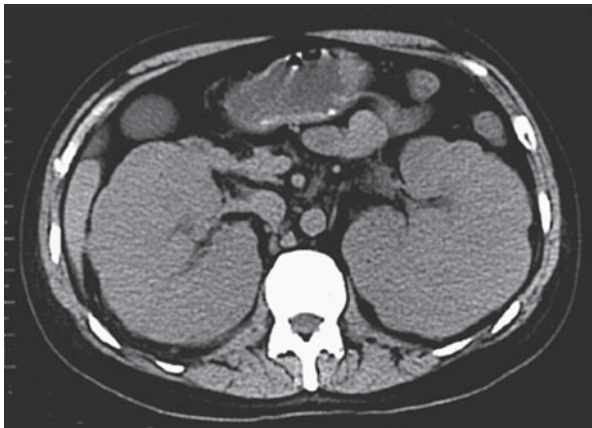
Computed tomography (CT) scan demonstrates bilateral kidney enlargement. Such nephromegaly is suggestive on an infiltrative process such as lymphoma (as in this case) and leukemia. (Courtesy of Mark A. Perazella.)
